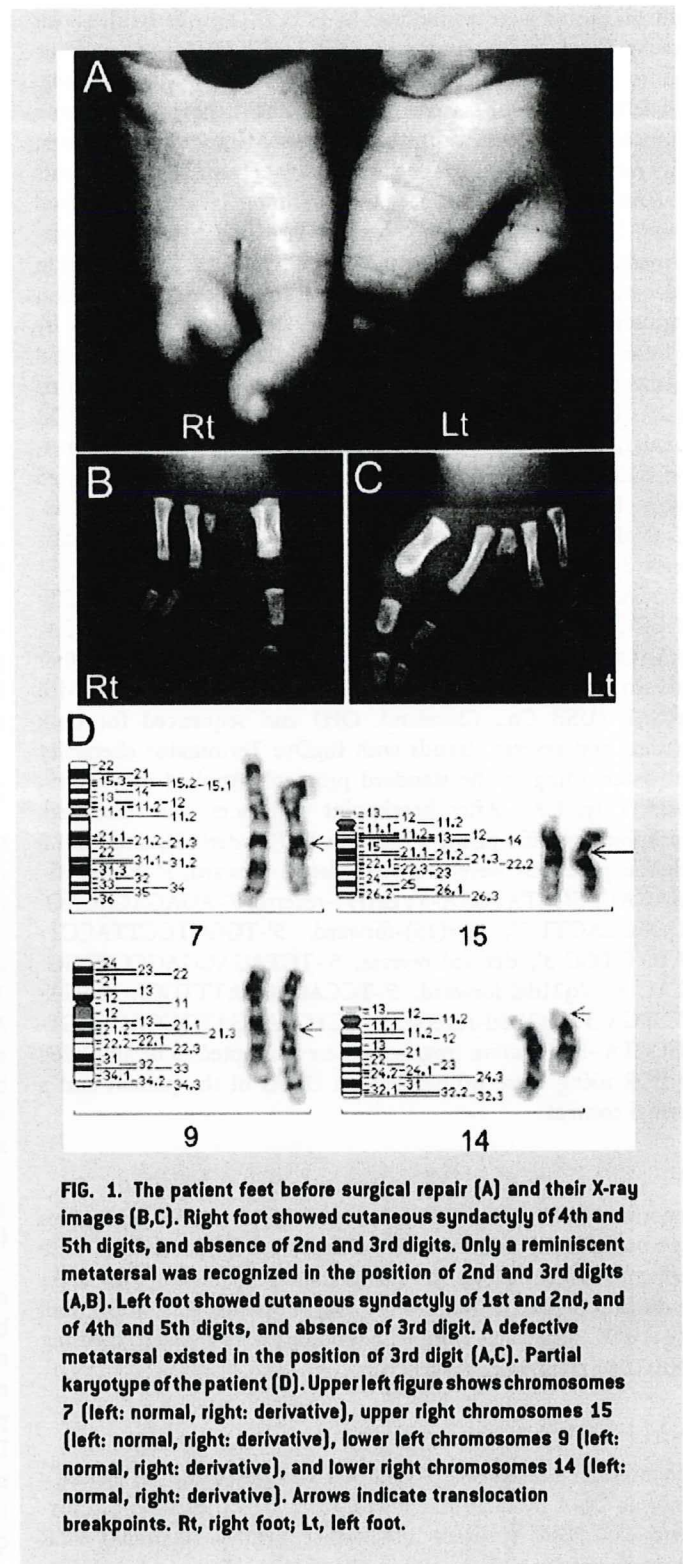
The patient feet before surgical repair (A) and their X-ray images (B,C). Right foot showed cutaneous syndactyly of 4th and 5th digits, and absence of 2nd and 3rd digits. Only a reminiscent metatarsal was recognized in the position of 2nd and 3rd digits (A,B). Left foot showed cutaneous syndactyly of 1st and 2nd, and of 4th and 5th digits, and absence of 3rd digit. A defective metatarsal existed in the position of 3rd digit (A,C). Partial karyotype of the patient (D). Upper left figure shows chromosomes 7 (left: normal, right: derivative), upper right chromosomes 15 (left: normal, right: derivative), lower left chromosomes 9 (left: normal, right: derivative), and lower right chromosomes 14 (left: normal, right: derivative). Arrows indicate translocation breakpoints. Rt, right foot; Lt, left foot.
